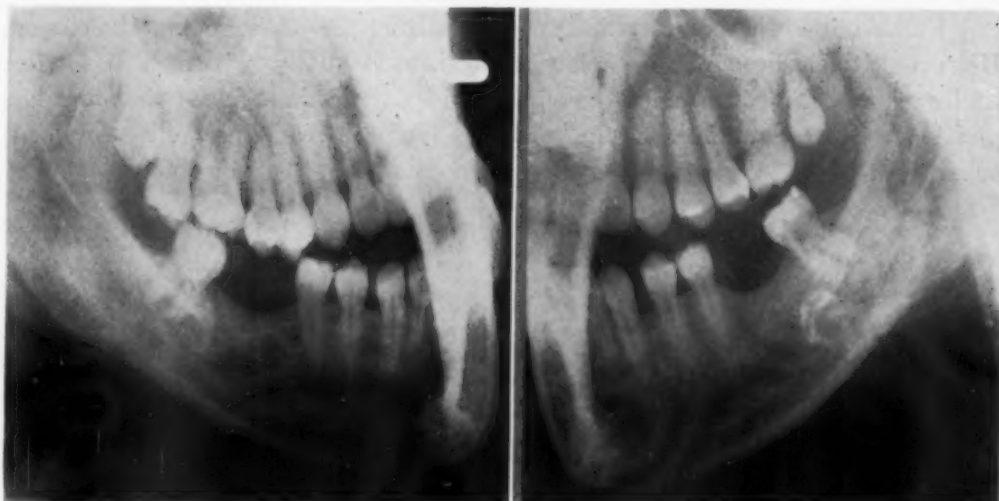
Roentgenograms of mandible before sectioning.
